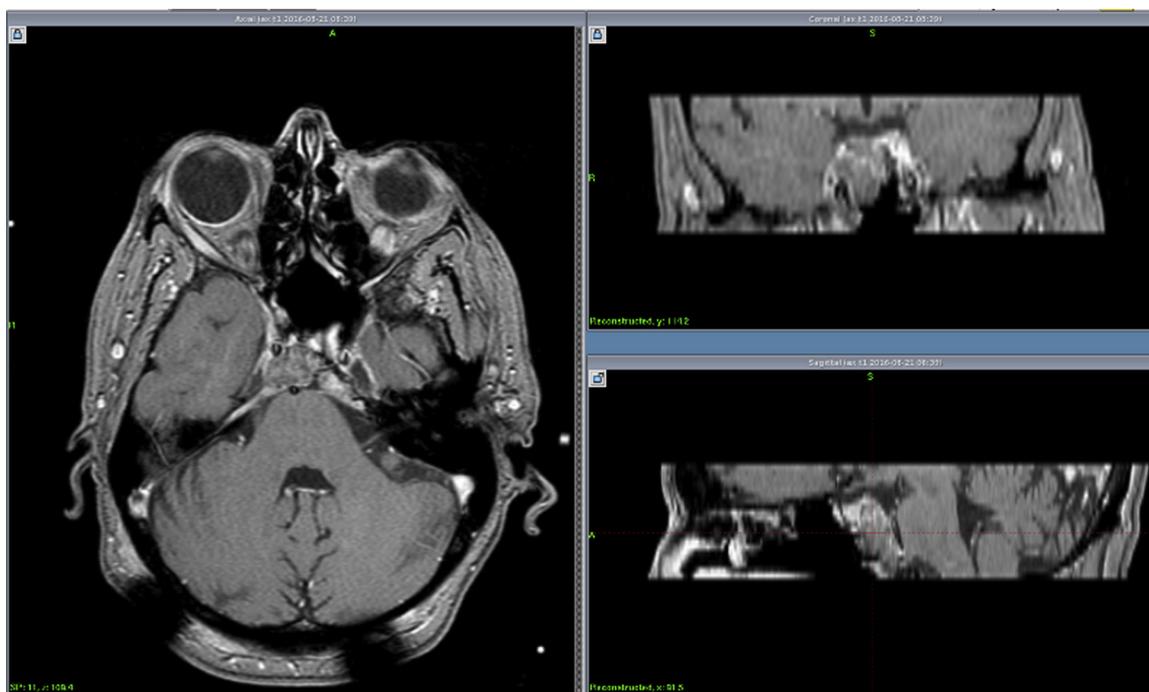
Stereotactic MRI of the same case in Fig. 1, after 2 years post 1st GKS showed lost tumor control outside radiation field with progressive regrowth of treated residual chordoma toward the right side that was retreated with gamma knife.
